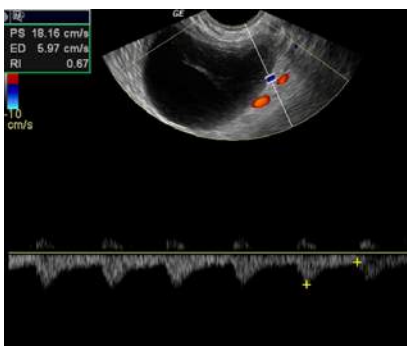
Transvaginal color Doppler scan. Same patient, spectral shows moderate high signal resistance (RI= 0.67)
